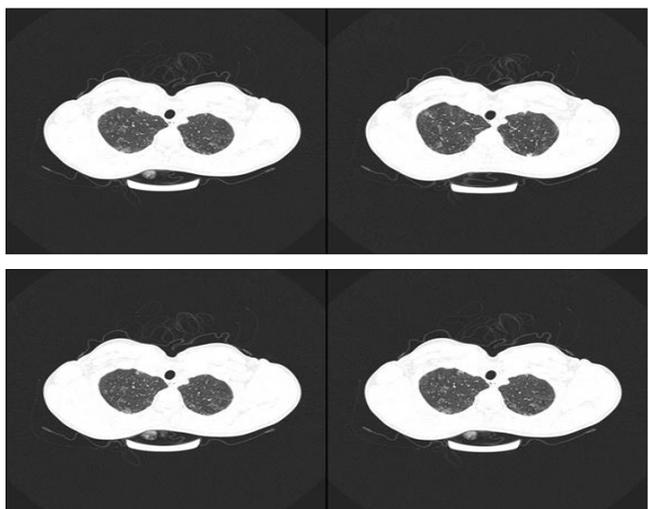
A CT axial image of the patient from 2016 showing bilateral pleural-based ground-glass appearance and consolidation areas
